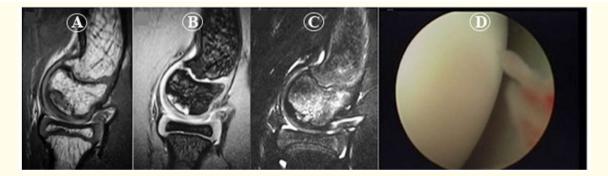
19D: Representative magnetic resonance imaging of stage 1 in a 12-year-old boy. A: The proton density-weighted image shows that the capitellum has a circular shape and no evidence of an abnormality of the articular cartilage. The osteochondritis dissecans lesion was identified beneath the articular cartilage on the B: T2 star-weighted image and C: T2-weighted fat-saturated image. D: Intraoperative arthroscopic view of the lesion showed no abnormalities of the articular cartilage.
